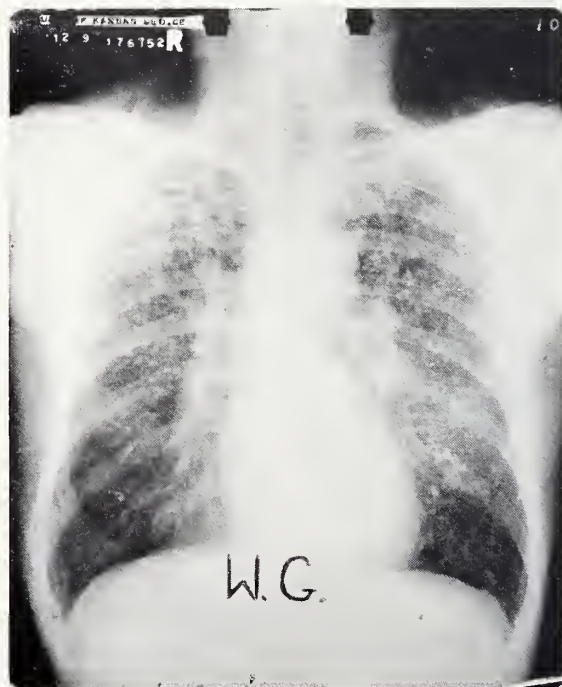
(W. G.) Admission PA chest roentgenogram. Demonstrates widespread fibrocalcific nodules with radiolucent area in right upper lobe.
